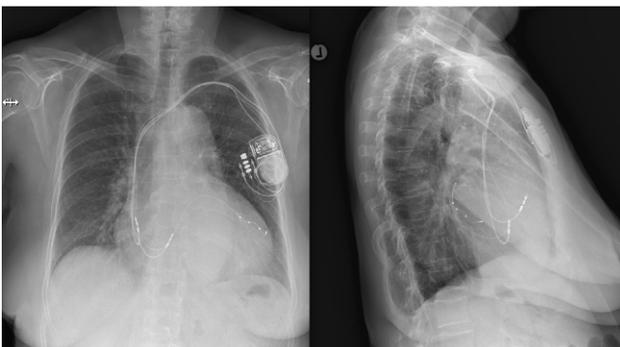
5-1 Chest X-ray of a female patient with a LOT-CRT
